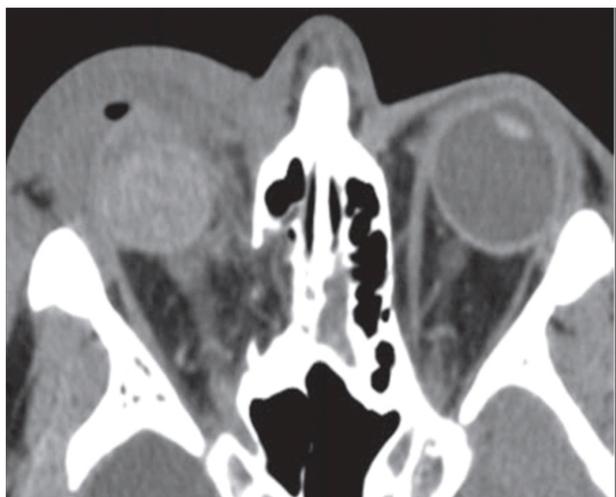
CT shows ruptured right globe with subcutaneous emphysema, soft tissue swelling and fracture of the medial orbital wall.
